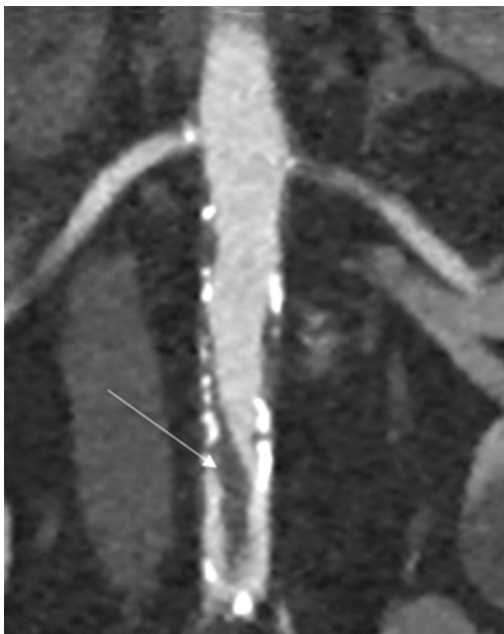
Computed tomography angiography showing floating thrombi in the infrarenal aorta of a 70-year-old female.
